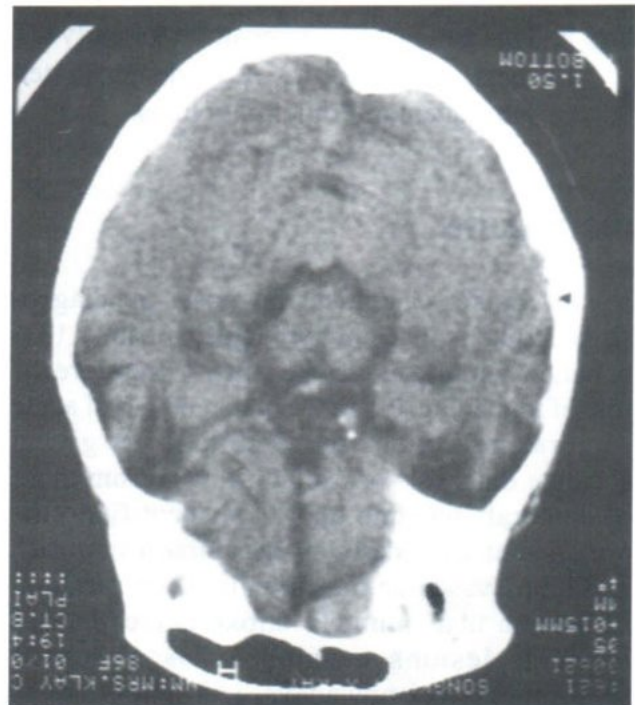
Hyperdense Middle Cerebral Artery Sign (HMCAS). The patient unenhanced CT showing left hyperdense sign (HMCAS), this patient developed subsequent large infarction.
